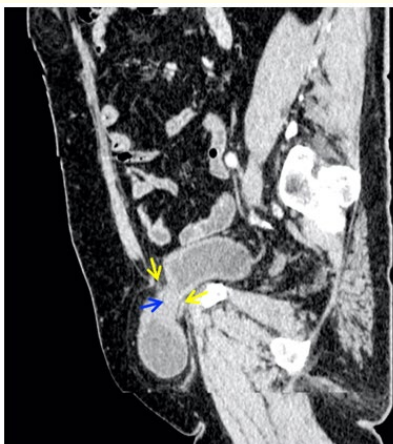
Sagittal view of an abdomino-pelvic CT scan showing a right inguinal bladder hernia (red arrow), with associated parietal thickening and partial sliding of the bladder through a narrow inguinal orifice, and intra-hernial effusion.
